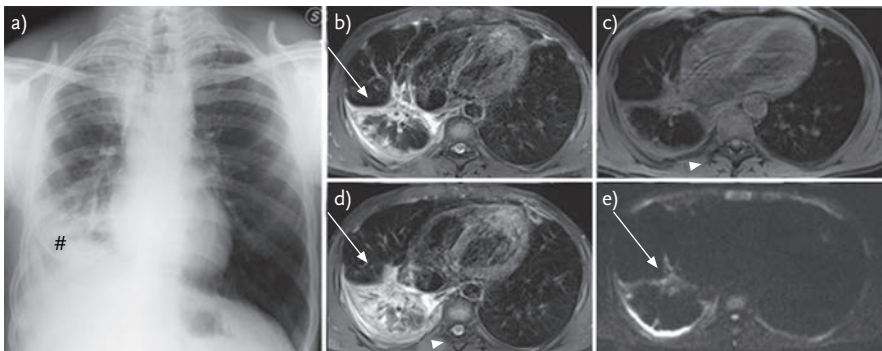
A 12-year-old boy with dyspnoea following lung transplantation. a) The chest radiograph showed an opacity in the right lung (#). b, d) T2-weighted fat saturation images clearly demonstrate a pneumonic infiltrate (arrows), e) confirmed with a particularly high signal in diffusion weighted imaging (arrow), associated with posterior hyperintensity in T2-weighted imaging (arrowheads) and c) hypointensity in T1-weighted imaging (arrowhead) indicating pleural effusion.
